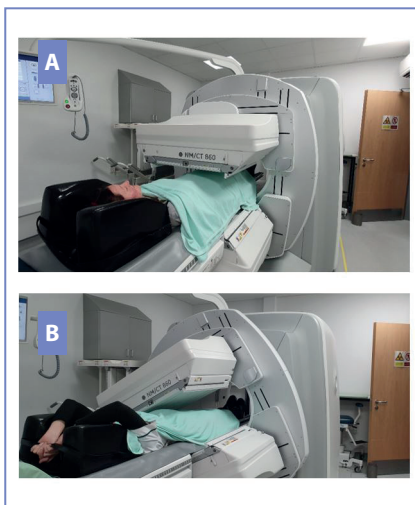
Patient positioning for sentinel lymph node imaging with arms by their sides (A) for planar imaging and with arms raised over the head (B) for SPECT/CT imaging. *Courtesy of the Department of Nuclear Medicine, The Christie NHS Foundation Trust, Manchester.*
